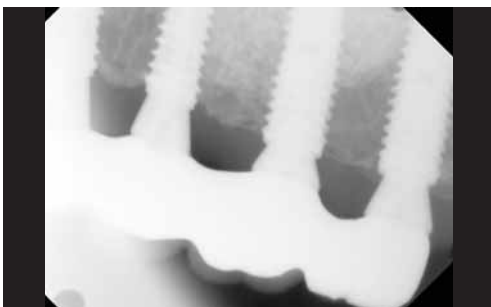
Periapical x-ray after 5 years. Minimal bone loss around implants is observed.
